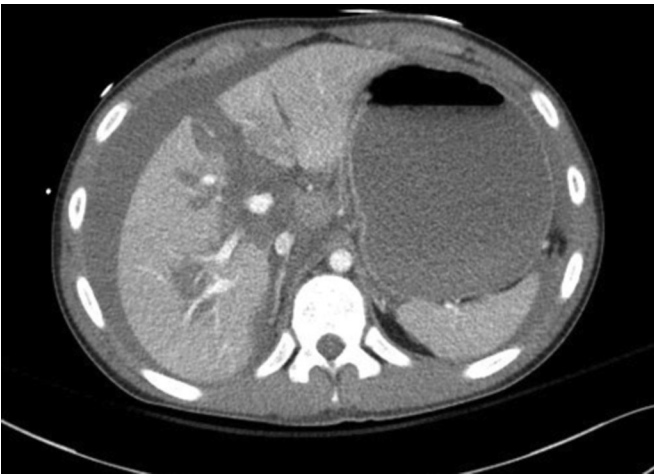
Abdominal computed tomography scan obtained at initial resuscitation demonstrating Grade V liver injury.
